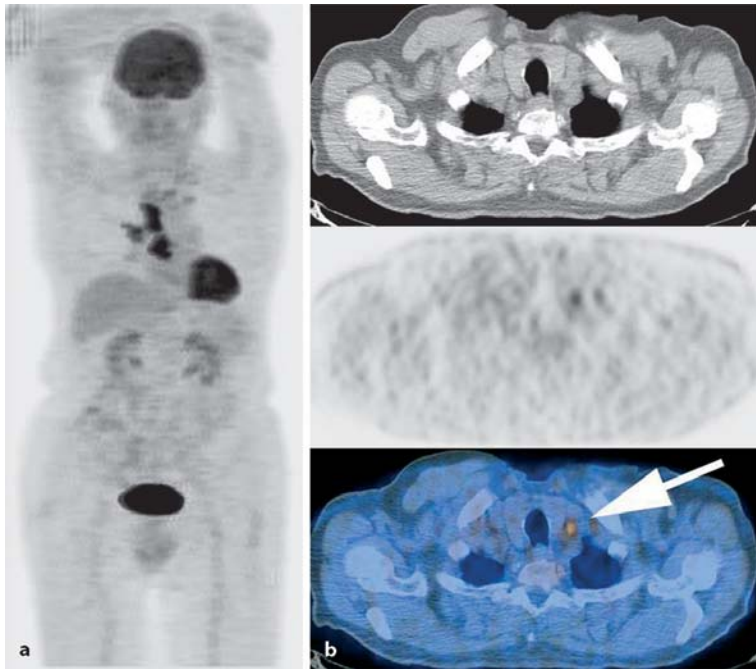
a, b. A 68-year-old male patient with a para-central squamous cell carcinoma of the lower lobe, referred for staging with FDG-PET/CT. Maximum-intensity projection (MIP). a FDG-avid lesions in the infra-carinal and ipsilateral mediastinal region as well as the peribronchial region on the right side. Unfortunately, a metastasis is seen on the contralateral para-vascular site (b) and in a scalenus lymph node on the left side (*arrow*), resulting in an inoperable stage IIIB
